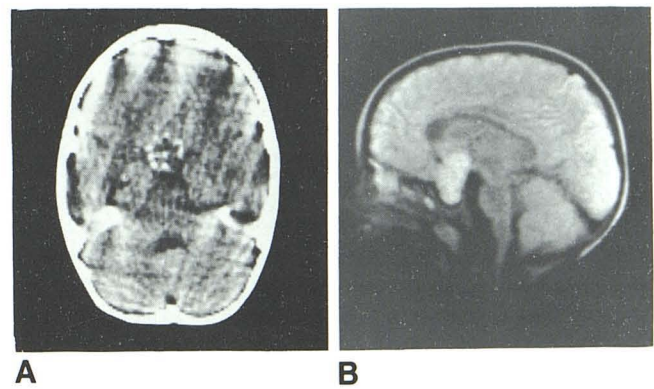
Craniopharyngioma. CT (A) and sagittal SE 1580/80 (B) images. Calcification in sellar and parasellar regions (A). Tumor has slightly increased T2 and extends through sella into sphenoid sinus (B).
